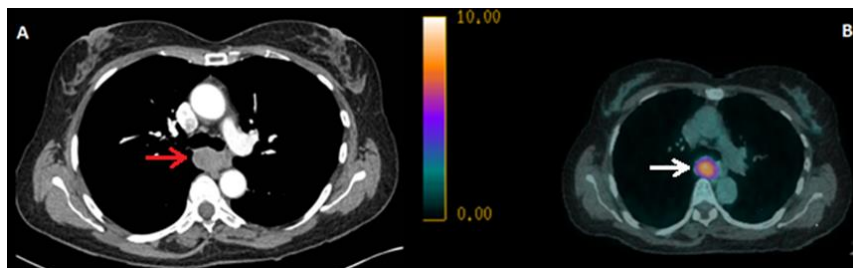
A) Computed Tomography (CT) scan of the chest showing a well-defined para-oesophageal mass in the posterior mediastinum and especially in the subcarinal area (red arrow) B) FDG-CT-PET scan of the chest showing an FDG avid subcarinal mass (white arrow)
